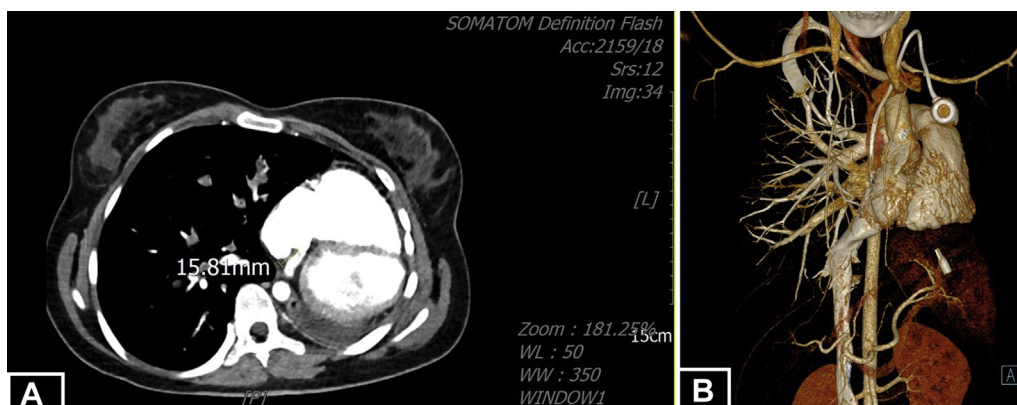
(A) Panel depicts the chest computed tomography with 1 measured thrombus. (B) Panel shows the 3-dimensional model of the patient's pulmonary circulation before the procedure. A vascular port device is present.
